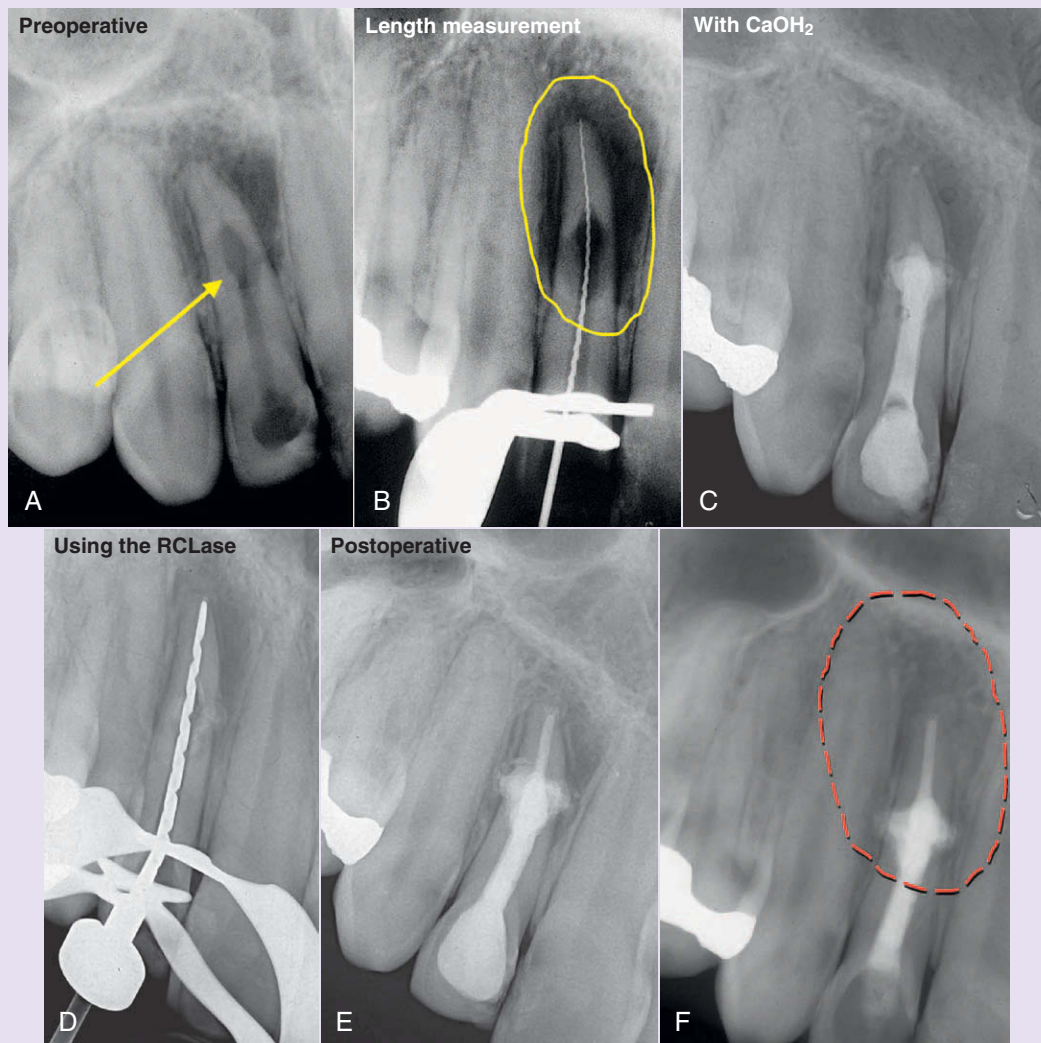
• Laser-assisted root canal filling. A, Preoperative radiographs of upper-right maxillary incisor showing internal resorption. B, A root perforation is visible on the measurement radiograph. C, Tooth filled with calcium hydroxide. D, Laser tip in canal. E, Lateral maxillary incisor after completion of root canal filling using hot gutta-percha technique. F, Two-year follow-up radiograph reveals complete healing of periapical lesion. Sinus tract disappeared, and patient is free of symptoms.
